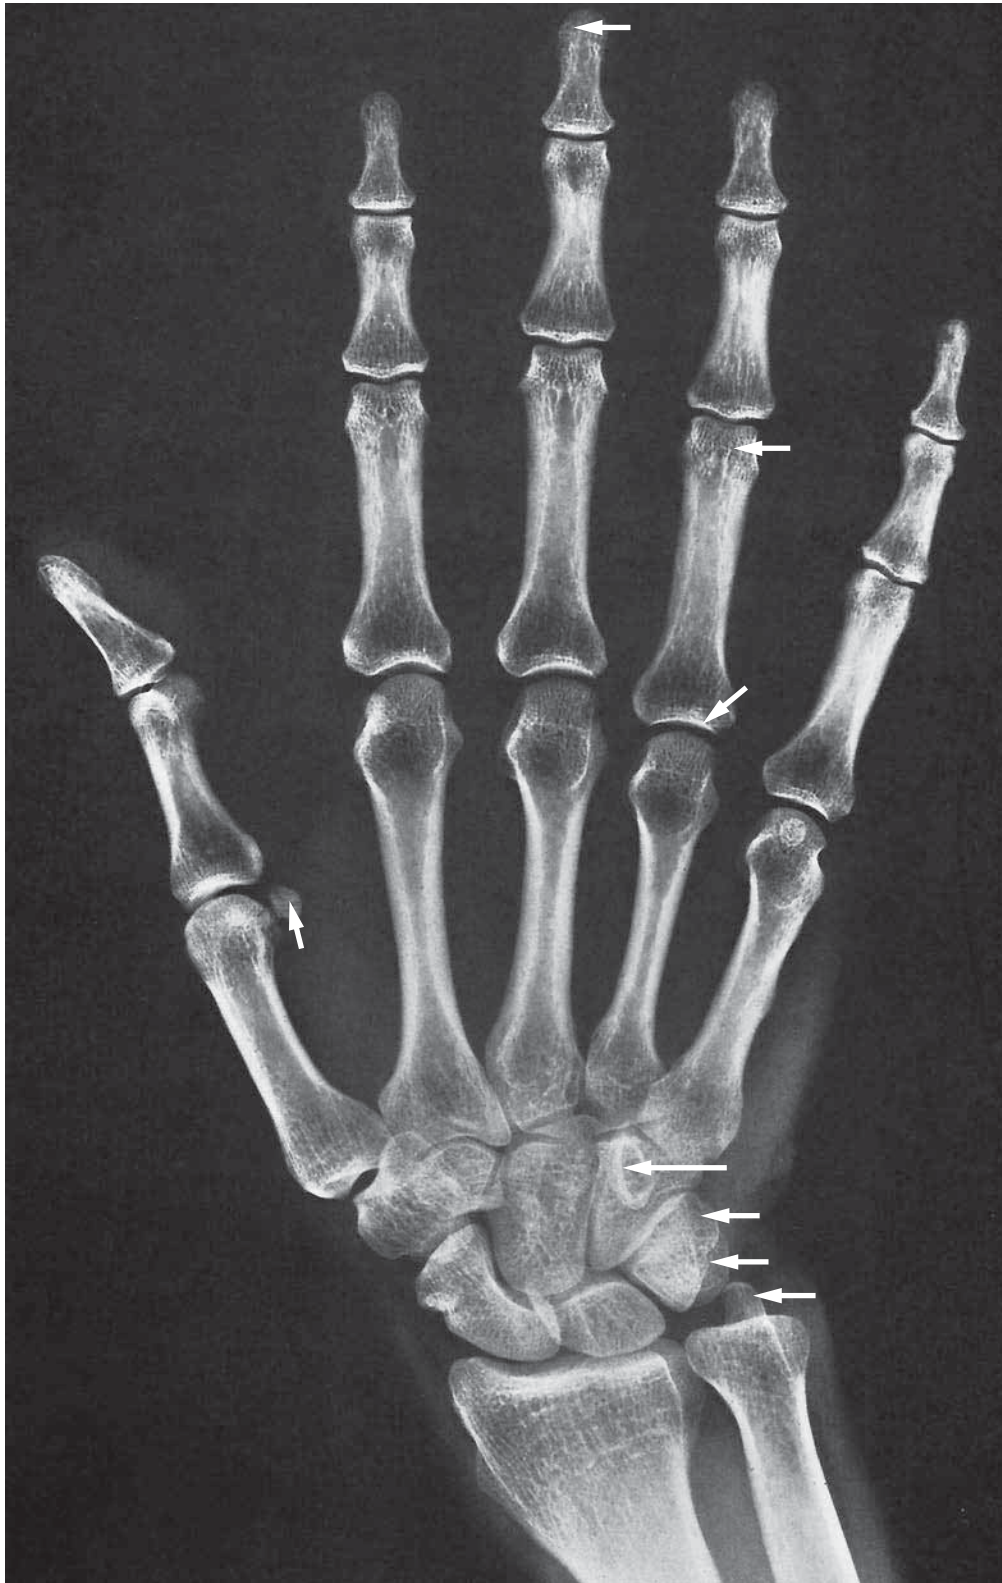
Radiograph of the Right Wrist and Hand (Dorsopalmar View)
